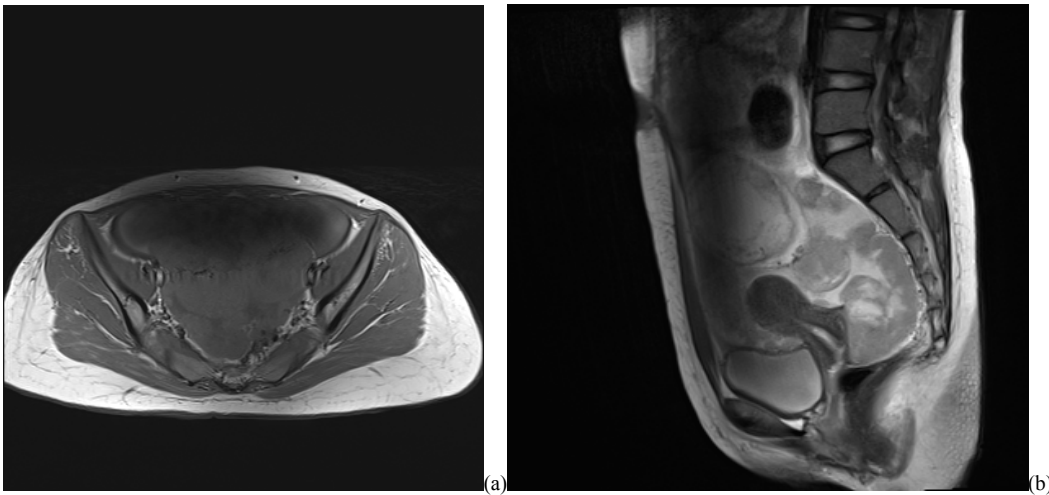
MRI findings of the pelvic tumor, as shown on the axial T1 weighted (a) sagittal T2 weighted (b) images, revealed a complex heterogeneous mass that filled the pelvic cavity on both sides and also in the presacral region. The mass also showed intermediate signal intensity and high signal intensity on T1WI and T2WI respectively. The mass also showed small regions of T1 high signal intensity compatible with intratumoral hemorrhagic foci.
